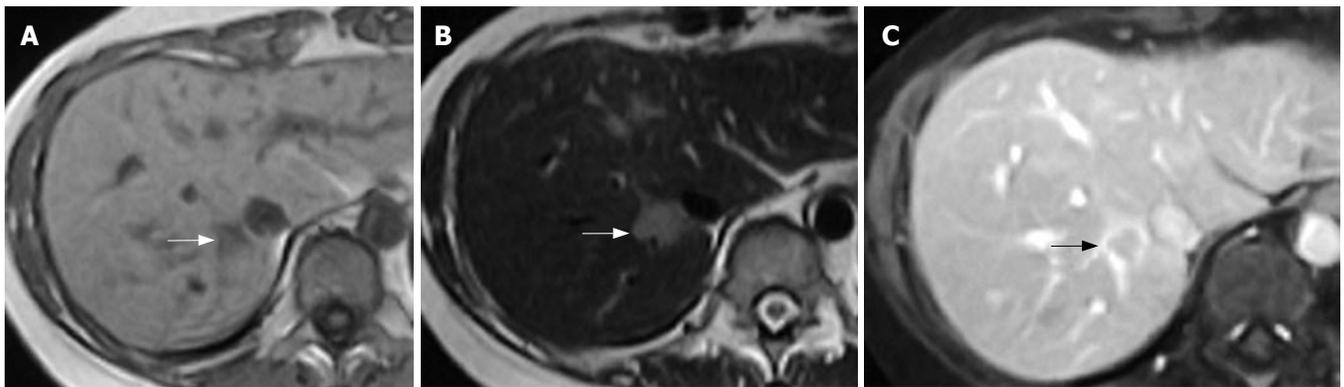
MRI displaying a hypointense signal on T1-weighted imaging (arrow) (A), a hyperintense signal on T2-weighted imaging of the lesion (arrow) (B), and enhanced tumor rim in the delayed phase of MRI (arrow) (C).
